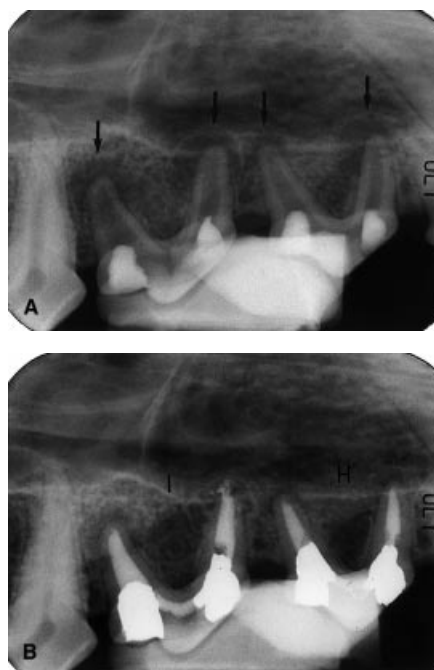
(A) Radiograph confirming the presence of apical radiolucencies on each root of the treated premolars (arrows). (B) Radiograph of the same teeth, 6 months postobturation showing healing (H) on one tooth or improvement (I) on the other.
